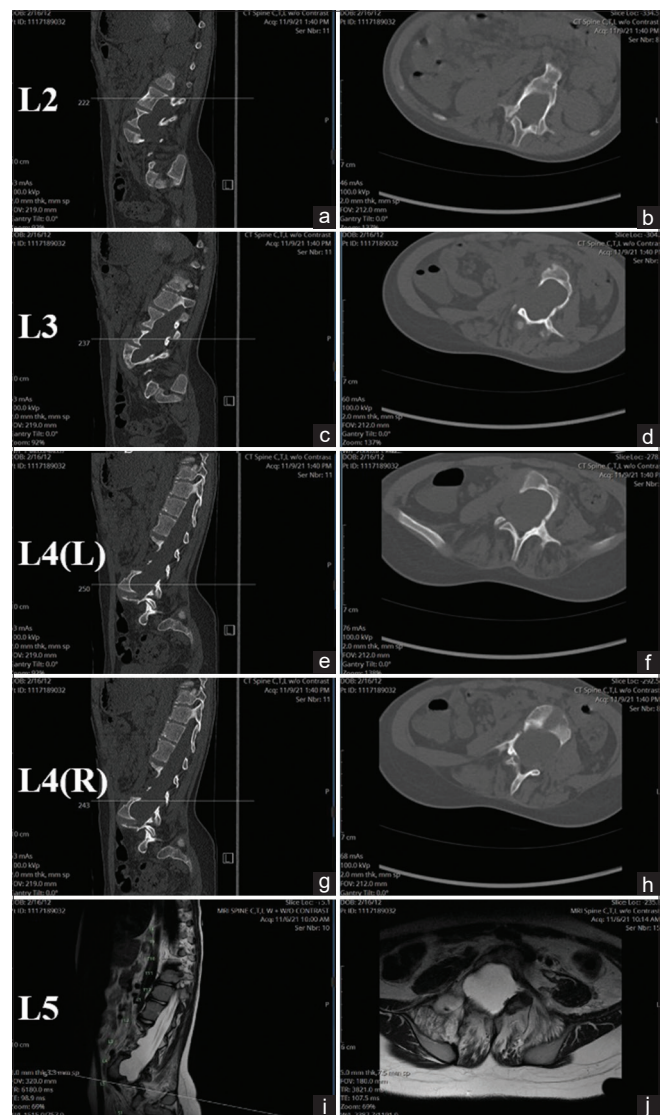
Preoperative computerized tomography images of the patient in the sagittal views at the levels of L2 (a), L3 (c), left side of L4 (g), and right side of L4 (g) alongside computerized tomography images in the transverse views at the levels of the patient alongside the L2 (b), L3 (d), sagittal views at the level of left side of L4 (e), left side of L4 (f), and right side of L4 (h). Preoperative sagittal (i) and transverse (j) magnetic resonance imaging views of the curve at the level of L5
